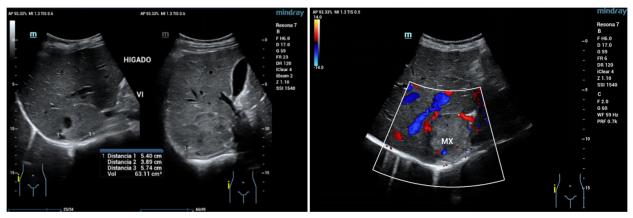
Images obtained via ultrasound: (a) in B-mode and (b) with color Doppler application. A solid-appearing mass is visualized superior to the right renal pole and in close contact with liver segment VI, according to Couinaud's anatomical classification. The mass appears isoechoic relative to the hepatic parenchyma, with well-defined margins and some hypoechoic areas within, suggesting necrosis, and displays peripheral vascular flow.
